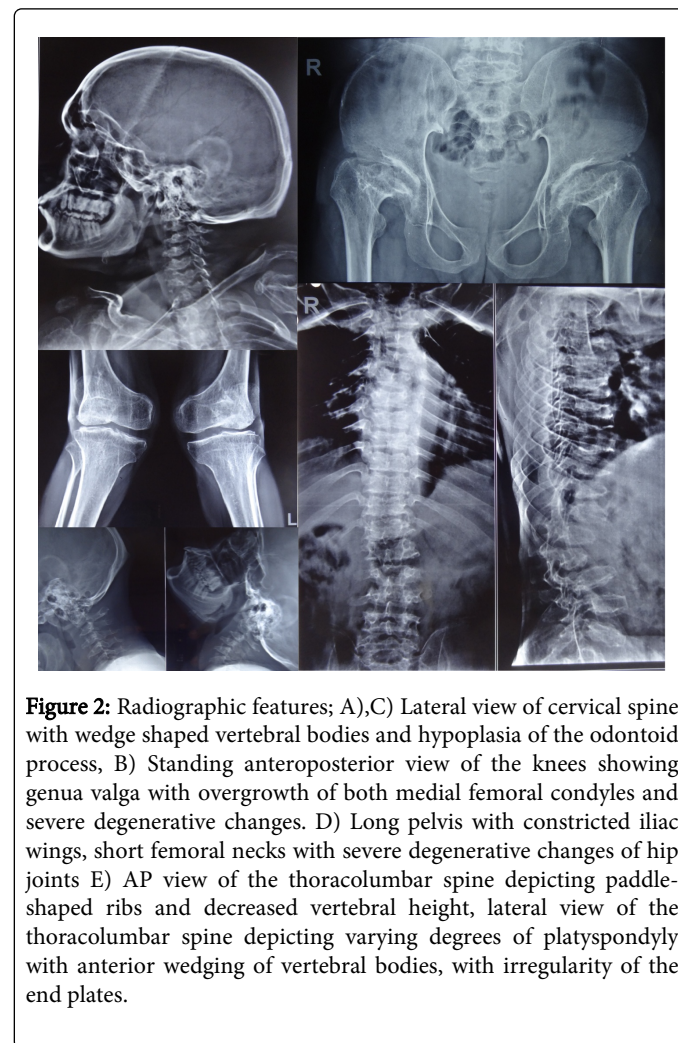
Radiographic features; A),C) Lateral view of cervical spine with wedge shaped vertebral bodies and hypoplasia of the odontoid process, B) Standing anteroposterior view of the knees showing genu valgum with overgrowth of both medial femoral condyles and severe degenerative changes. C) Long pelvis with constricted iliac wings, short femoral necks with severe degenerative changes of hip joints D) AP view of the thoracolumbar spine depicting paddle-shaped ribs and decreased vertebral height, lateral view of the thoracolumbar spine depicting varying degrees of platyspondyly with anterior wedging of vertebral bodies, with irregularity of the end plates.
